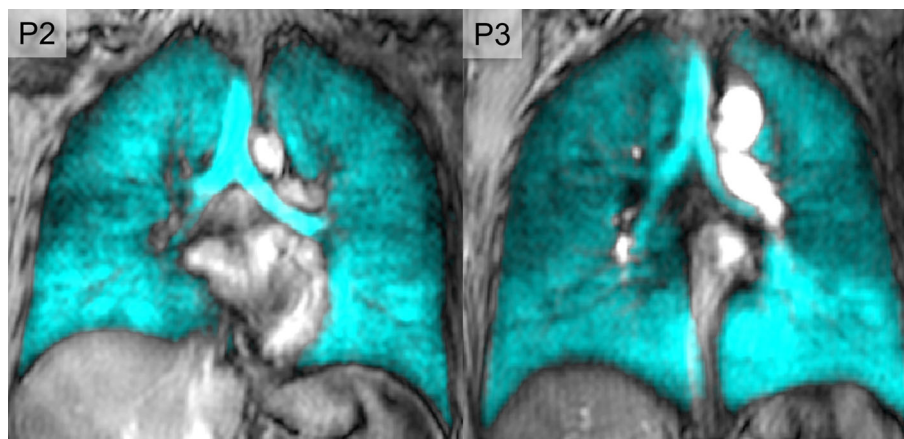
Hyperpolarized ^{129}Xe MRI ventilation MRI in representative healthy volunteers. Coronal ^{129}Xe MRI slices (cyan) co-registered with ^1H MRI thoracic cavity in two healthy participants (P2 and P3). Arrows identify ventilation abnormalities. P2 was a 30-year-old male with no prior diagnosis of chronic respiratory illness and $\text{FEV}_1 = 103\%$ and $\text{VDP} = 1\%$. FEV_1 = forced expiratory volume in 1 s; VDP = ventilation defect percent.
